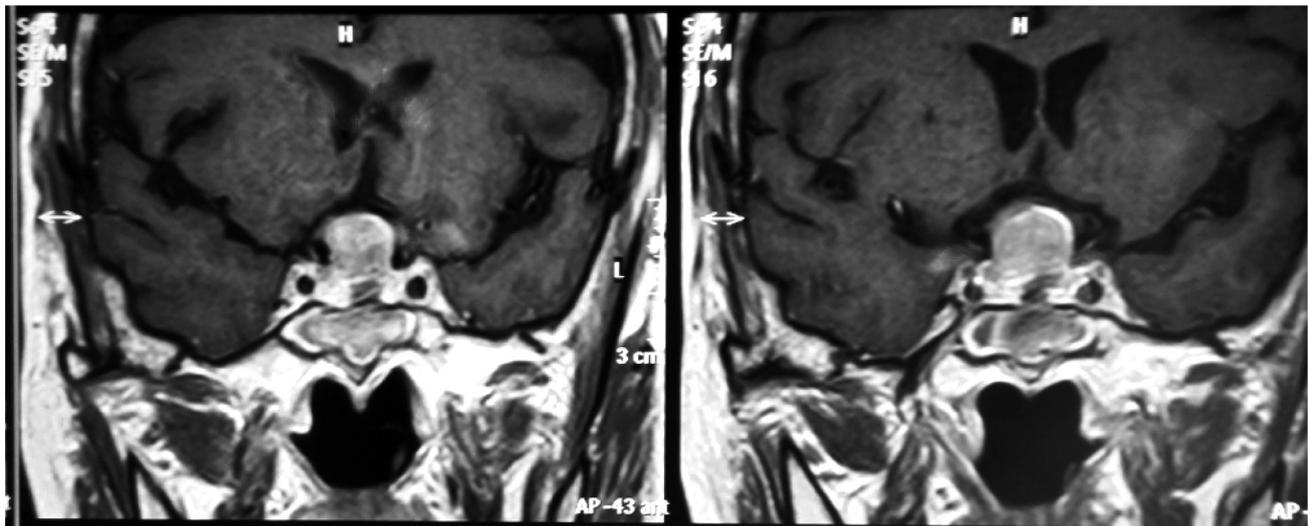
Postoperative contrast-enhanced MRI, coronal image of same patient with residual tumor more in left parasellar region.
